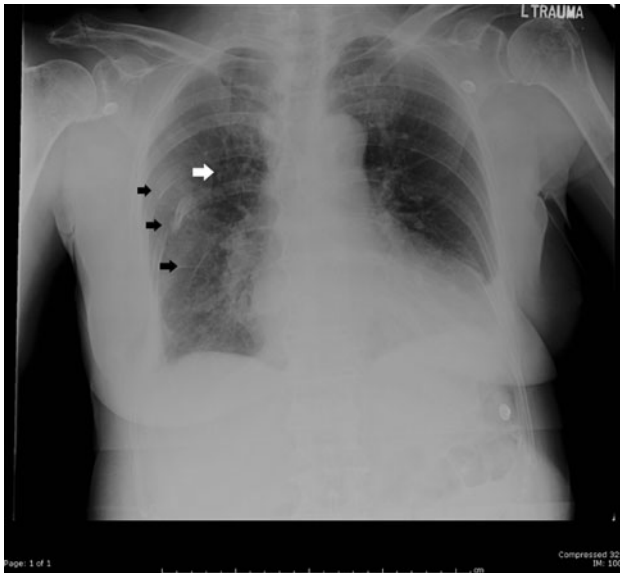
Initial posteroanterior chest radiograph showing right-sided posterolateral rib fractures and a small apical pneumothorax. The white arrow points to the edge of the collapsed lung, while the black arrows point to the displaced rib fractures
